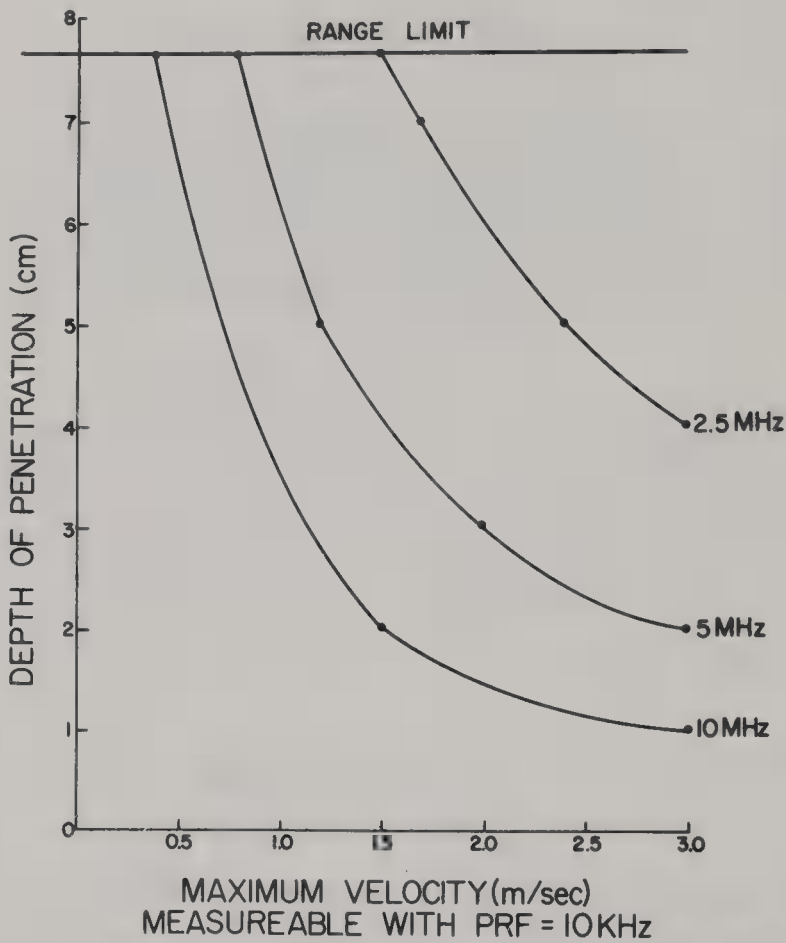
The effect of variation in transmission frequency on the penetration capability and maximum unambiguous velocity measurable by a pulsed Doppler system. (From Berman W, Jr (ed): *Pulsed Doppler Ultrasound in Clinical Pediatrics*. Mt Kisco, NY, Futura Publishing Co, 1983. Used by permission.)
